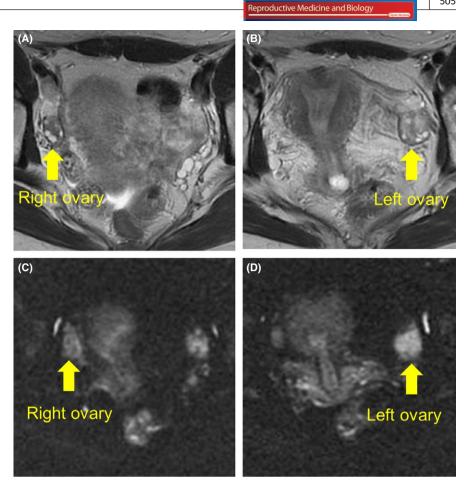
Magnetic resonance imaging of the ovaries. A and B, T2weighted images. C and D, Diffusionweighted images. The left ovary had a higher intensity area than that of the right ovary
